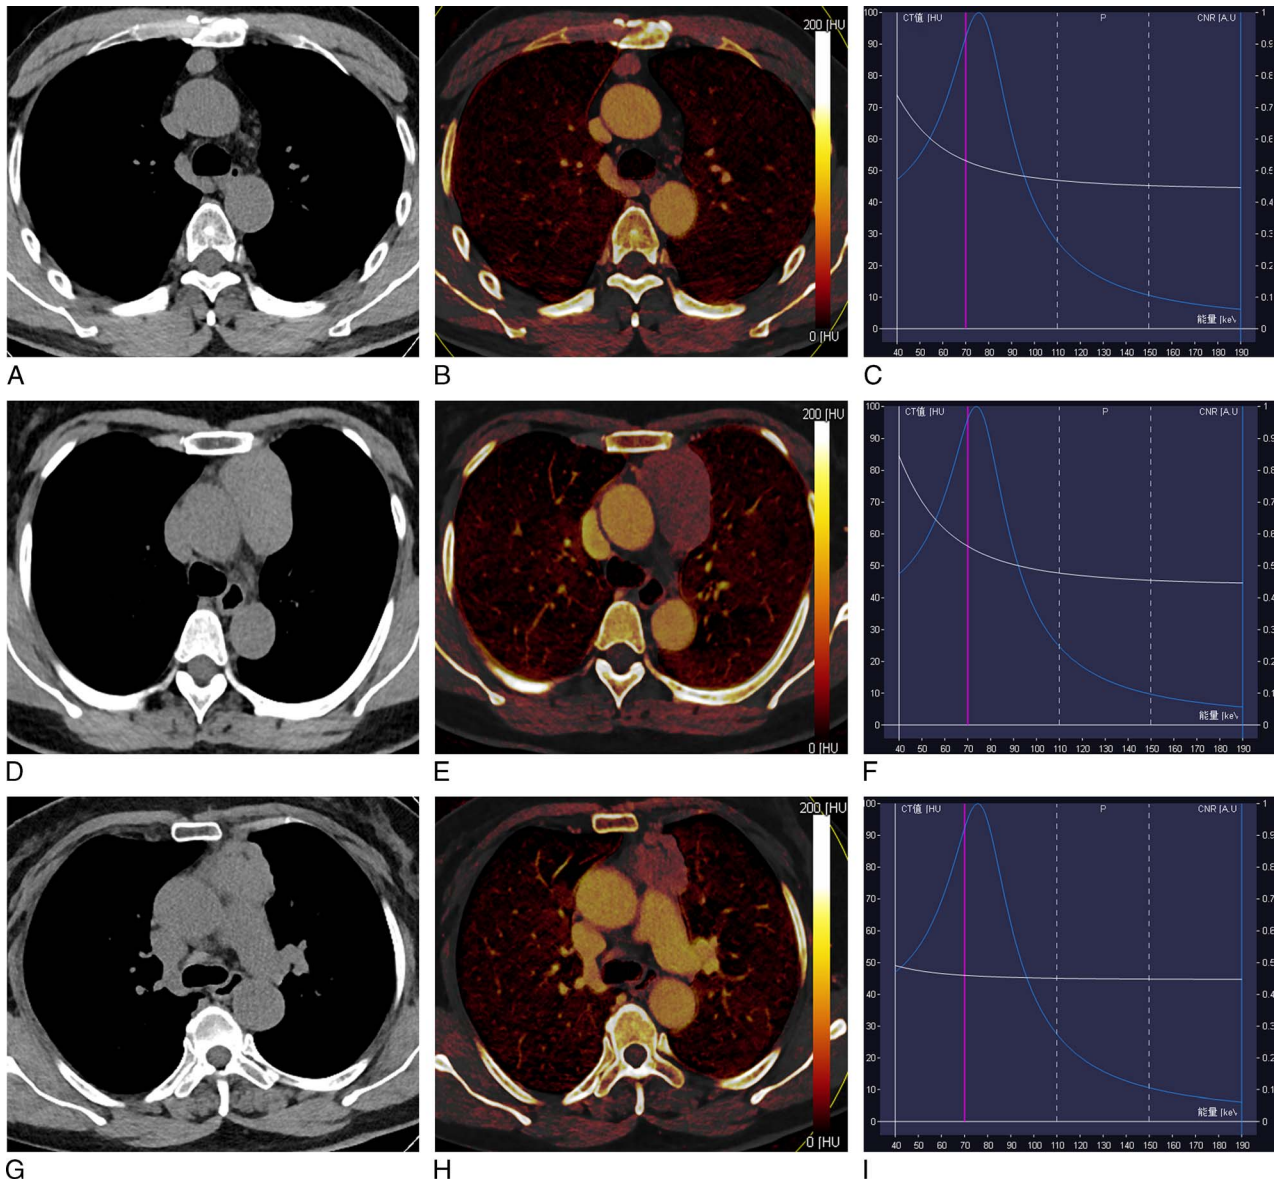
Dual-energy computed tomography images of representative thymoma cases. A–F, Low-risk thymoma (A–C: type A and D–F: type B1): (A) or (D) axial VNC CT image shows anterior mediastinal mass with oval shape and smooth contour; (B) or (E) axial iodine overlay image shows significant iodine color in thymic solid tumor, and iodine-related HU (IHU), IC, and MHU values in venous phase were 35.2 HU, 1.7 mg/mL and 83.9 HU for type A thymoma (B), 23.4 HU, 1.2 mg/mL, and 66.9 HU for type B1 thymoma (E), respectively; (C) or (F) graph of virtual monochromatic HU curves for the same region of interest locations shows much greater descending curve in tumor. G–I, High-risk thymoma (type B3): (G) axial VNC CT image shows anterior mediastinal mass with irregular contour and blurred fat layer of peritumor. H, Axial iodine overlay image shows moderate iodine color in tumor, and venous phase IHU, IC, and MHU values were 21.4 HU, 1.0 mg/mL, and 67.1 HU, respectively; (I) graph of virtual monochromatic HU curves for the same region of interest locations shows less steep descending curve in tumor. Figure 1 can be viewed online in color at www.jcat.org.
